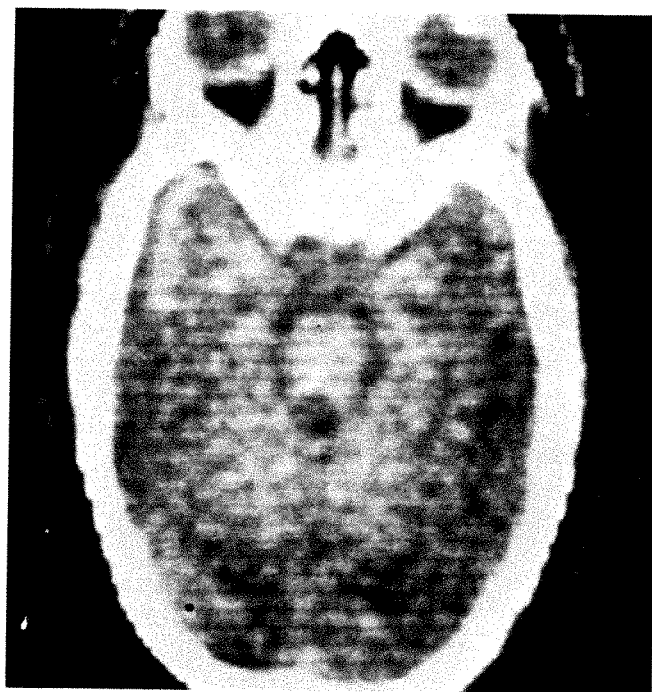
Meningitis. 2-month-old female febrile and comatose with bulging fontanel and focal right-sided seizures; diagnosis of *B*-streptococcal meningitis by culture of purulent cerebrospinal fluid. Clinical diagnosis of cortical infarction secondary to vasculitis made and supported by electroencephalogram which showed delta waves consistent with severe brain damage. Radionuclide brain scan showed diffuse peripheral uptake from frontal to occipital regions bilaterally. CT scan shows nonhomogeneous regions of decreased density consistent with infarction present diffusely in cortical areas of temporal lobes and in cerebellar hemispheres. Two months later patient remains in vegetative state.
